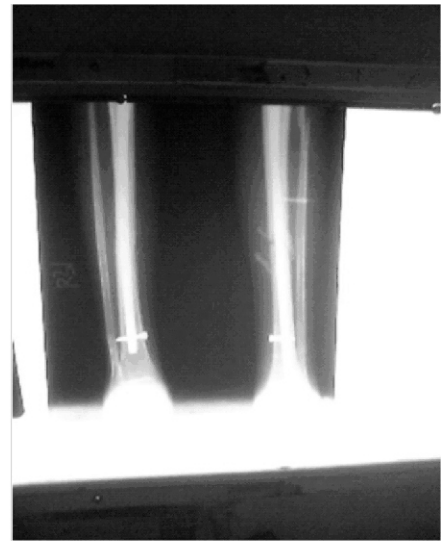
Post operative radiograph after one month
